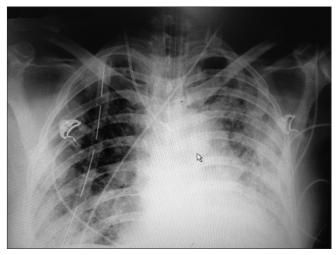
Post-procedure X-ray chest
